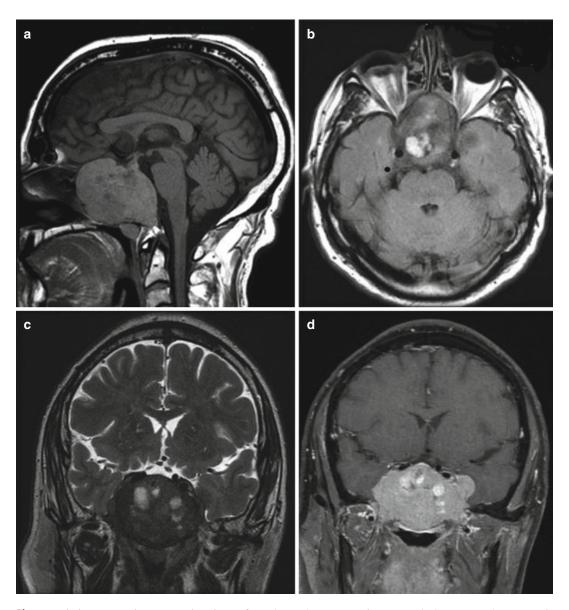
Pituitary magnetic resonance imaging performed in a patient with panhypopituitarism shows a large heterogeneous mass $(5.6 \times 6.0 \times 6.1 \text{ cm})$ involving the clivus, with intrasellar extension and infiltration of the sphenoid
